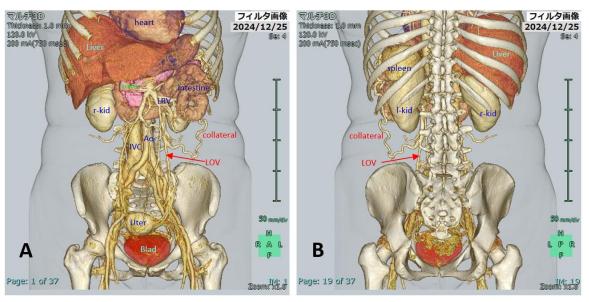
Reconstruction of Abdominal CT by Synapse Vincent
